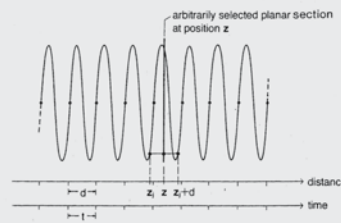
Principle of image reconstruction in spiral volumetric CT. Planar data for arbitrary table positions are calculated from the spiral data by means of linear interpolation.
